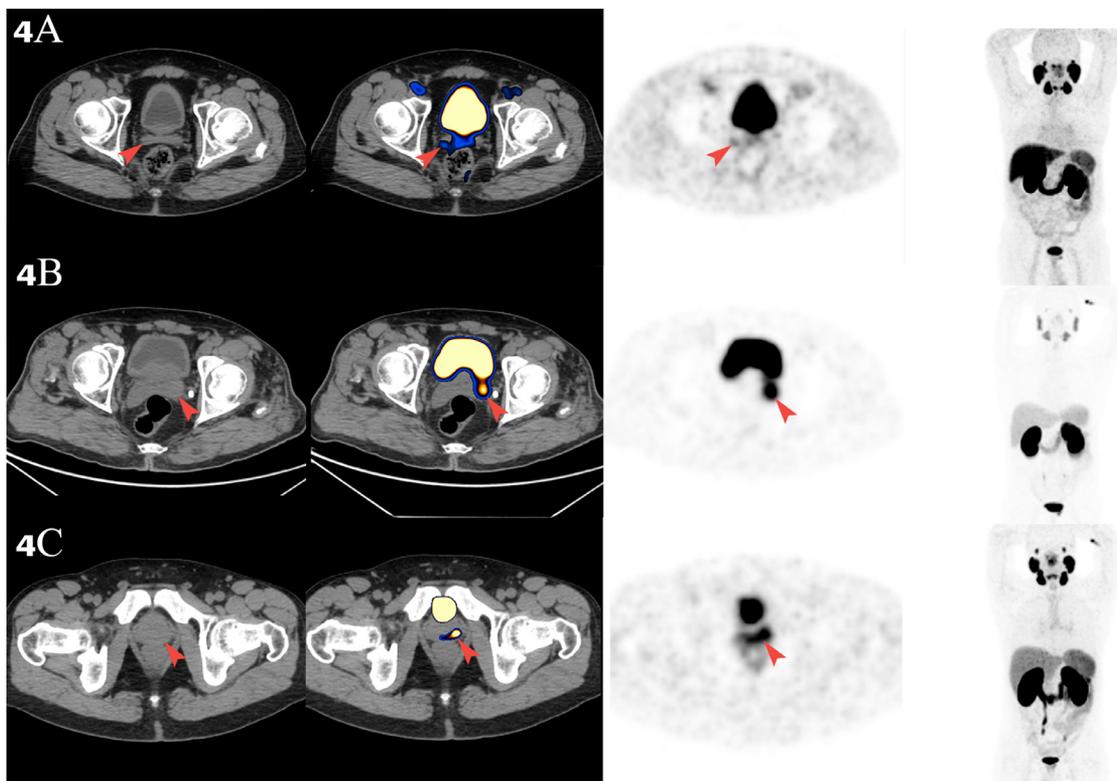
(A), False positive 68Ga-PSMA-11 focal uptake in the right seminal vesicle. (B), True positive 68Ga-PSMA-11 focal uptake in the left seminal-vesicle. (C), Extraprostatic extension on final pathology; could not be determined accurately on 68Ga-PSMA PET/CT.
